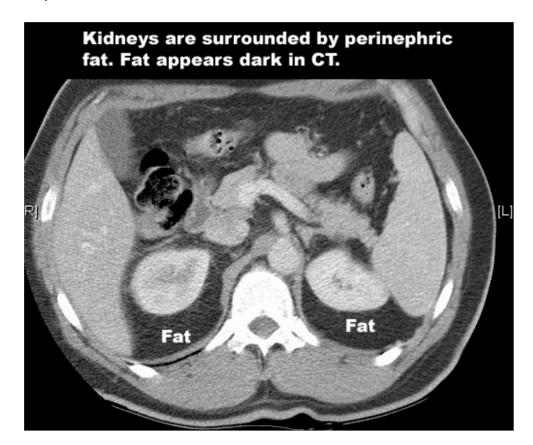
CT scan showing perinephric fat.
